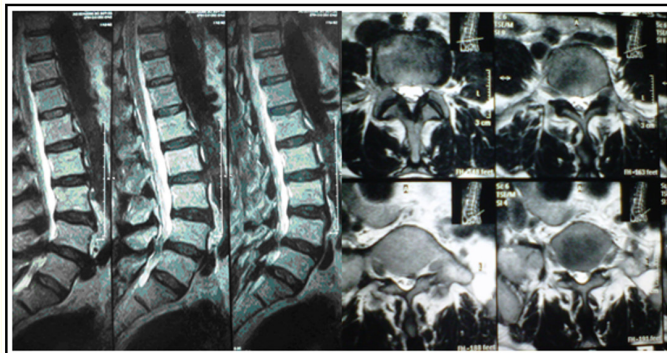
Preoperative Magnetic Resonance Imaging scans.
